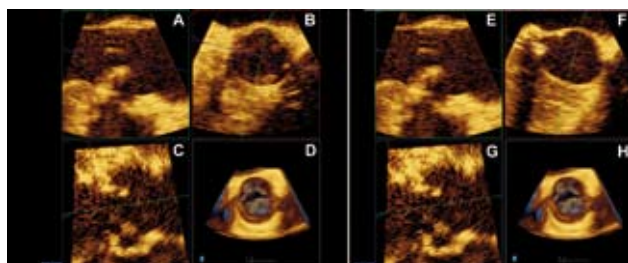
3D transesophageal echocardiography with the 3-chamber long axis views shown in panels A and E during systole. Cross-sectional views showed an elliptical shaped aortic annulus (panel B) and left ventricular out flow tract (panel F).
